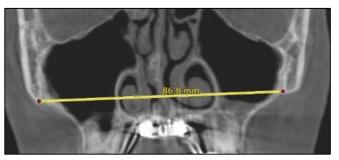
"J" parameter: CBCT image in the coronal plane.
